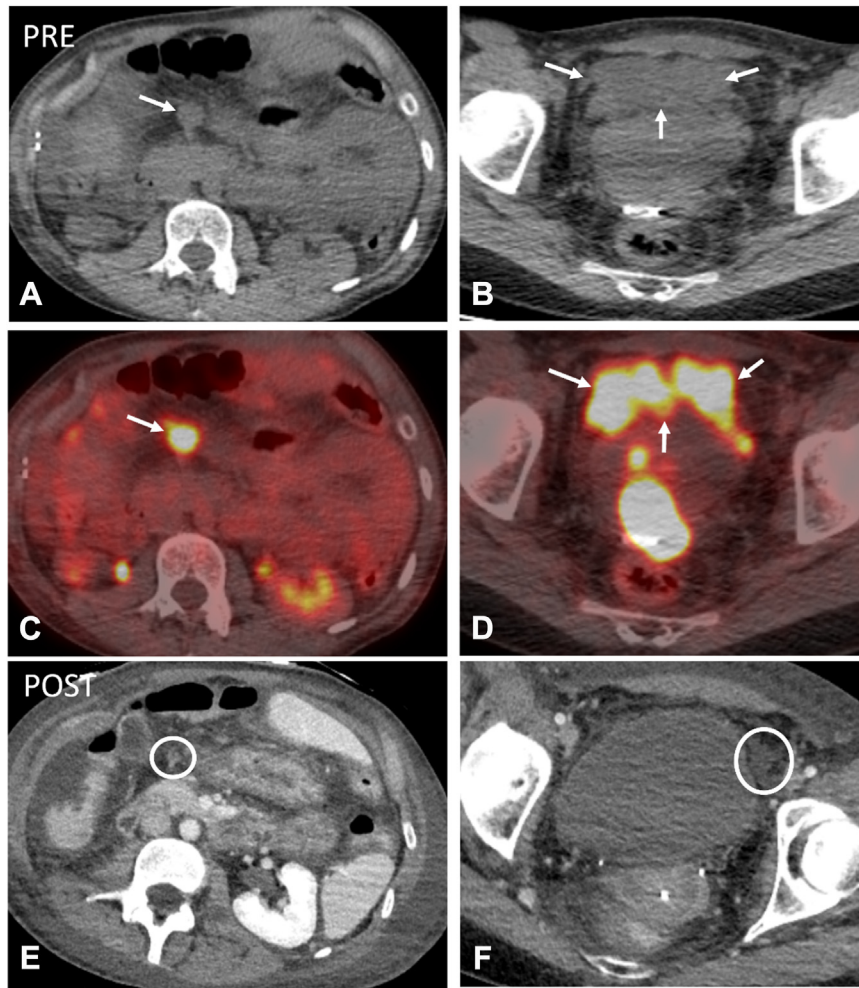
Pre and posttreatment imaging. PET CT images before therapy (A-D) including axial localizing CT images in soft tissue window (A and B) and fused corresponding fused PET CT images (C and D) showing metabolically active mesenteric soft tissue implants (arrows; A and B) and an infiltrative prevesical soft tissue lesion (arrows, C and D) compatible with disease involvement. Axial images in soft tissue window from follow-up abdominal CT 4 months after treatment (E and F) showing substantial treatment response with nearly resolved mesenteric implant (circle, E) and resolved prevesical soft tissue infiltration with trace ascites (circle, F). CT, computed tomography; PET, positron emission tomography.
